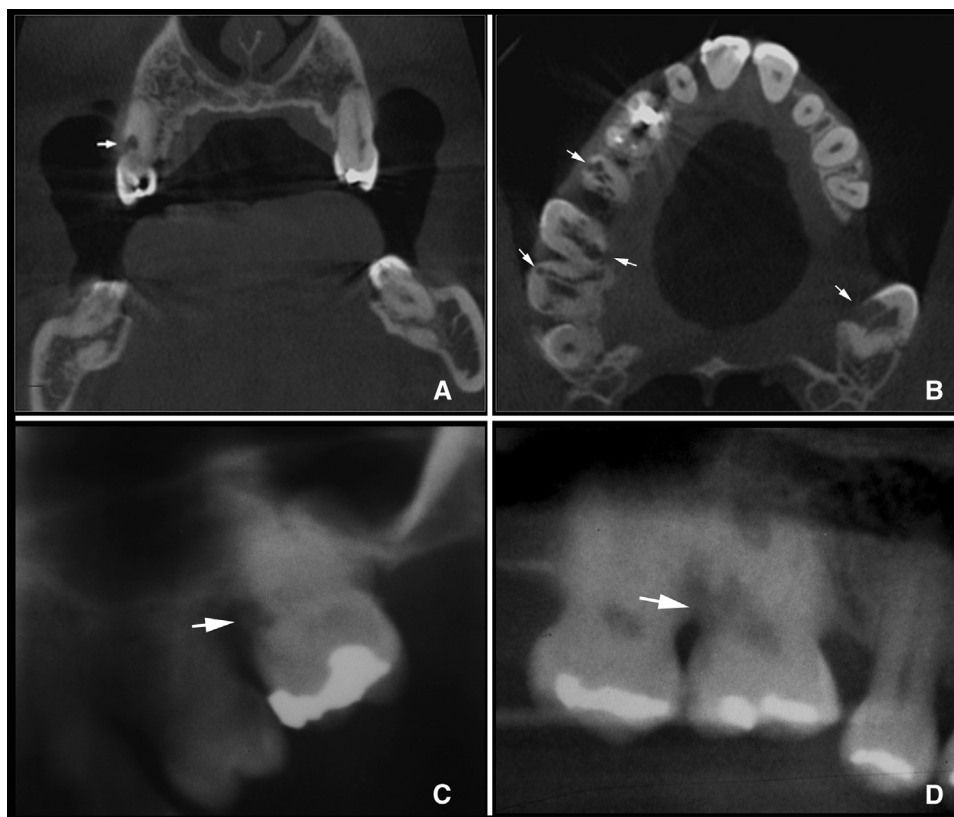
A and B, Tomographic images of patient II.12 at age 40, showing multiple cervical resorptions in posterior maxillary teeth (*arrows*); note the subgingival position of root resorptions. Details of the panoramic radiographs of C, patient I.2 and D, patient II.11, showing radiolucencies with scalloped margins at the cemento-enamel junction.
